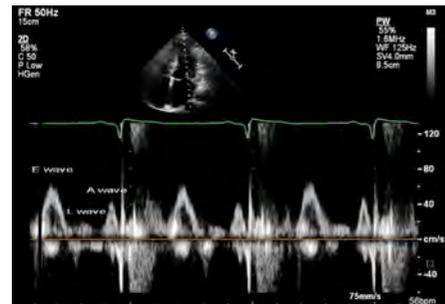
Triphasic mitral inflow pattern in Doppler echocardiography.
